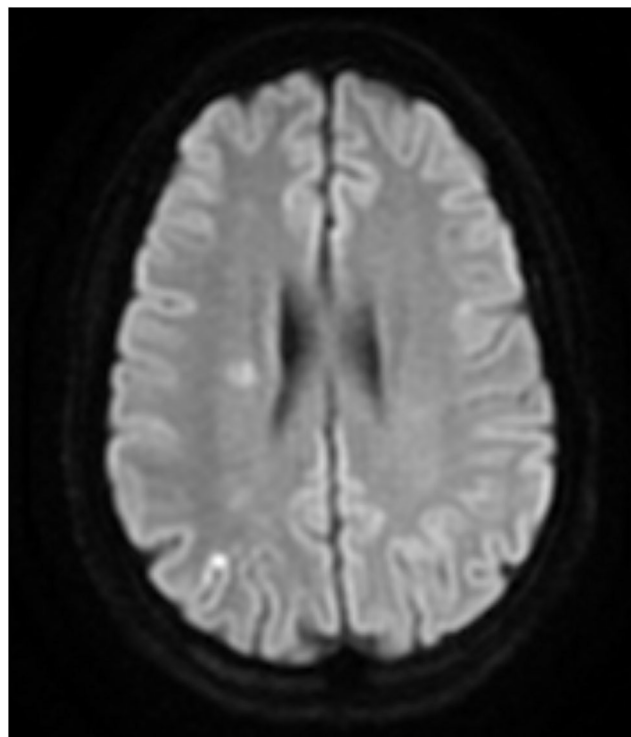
MRI DWI sequence of Mixed Infarct.
